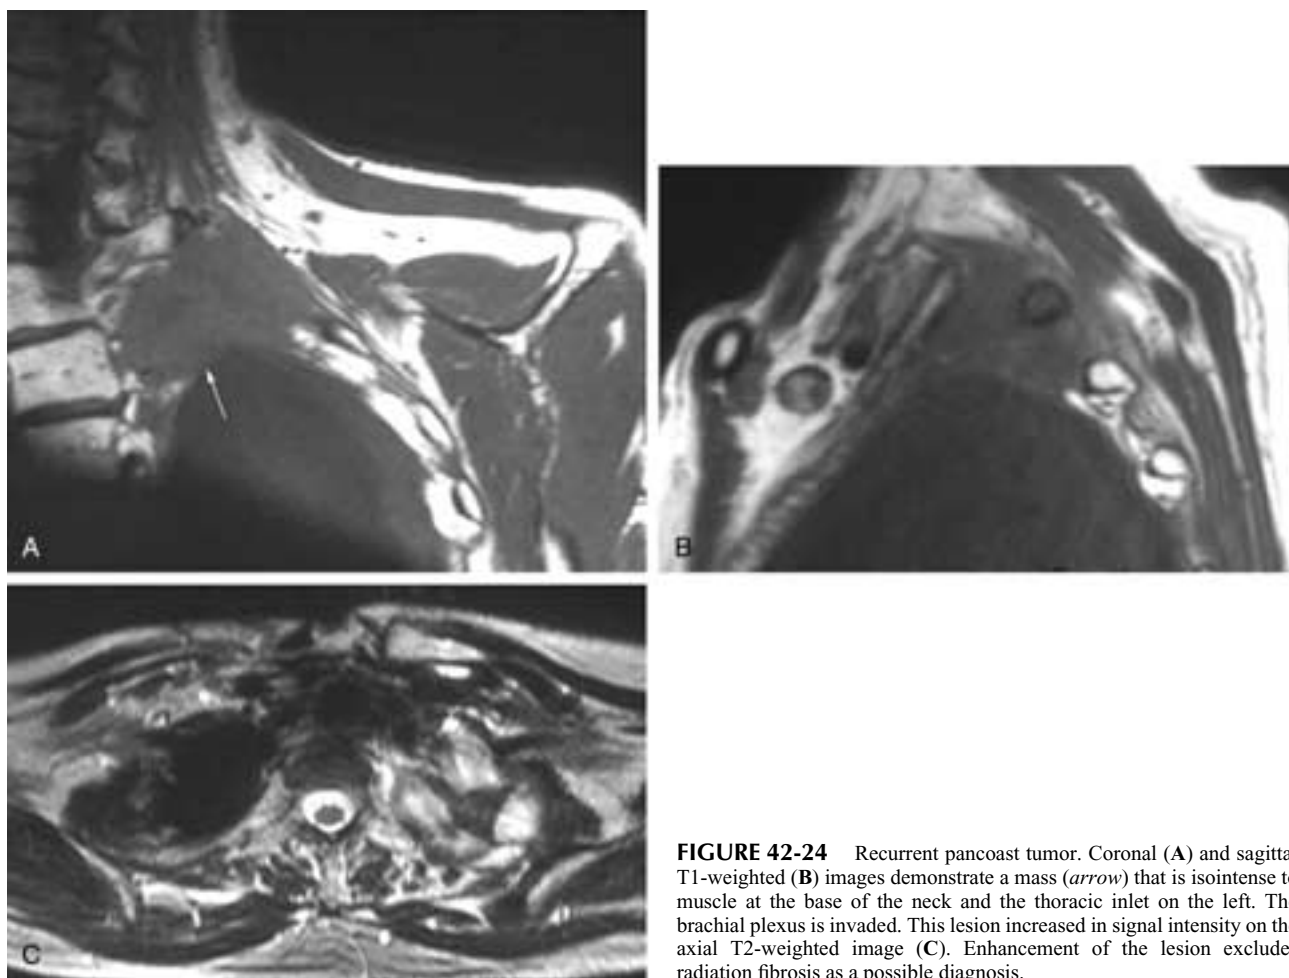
Recurrent pancoast tumor. Coronal (A) and sagittal T1-weighted (B) images demonstrate a mass (arrow) that is isointense to muscle at the base of the neck and the thoracic inlet on the left. The brachial plexus is invaded. This lesion increased in signal intensity on the axial T2-weighted image (C). Enhancement of the lesion excludes radiation fibrosis as a possible diagnosis.
